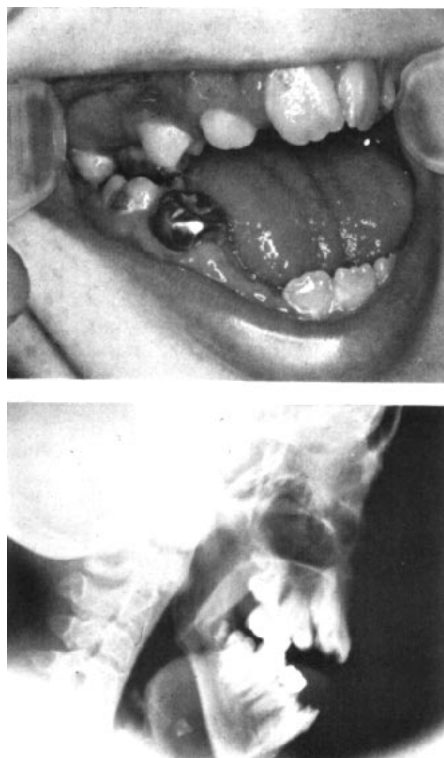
Above, severe anterior open bite (26 mm) in ten year old girl with a generalized muscular weakness syndrome; below, cephalometric radiograph showing extreme downward and backward rotation of the mandible.
